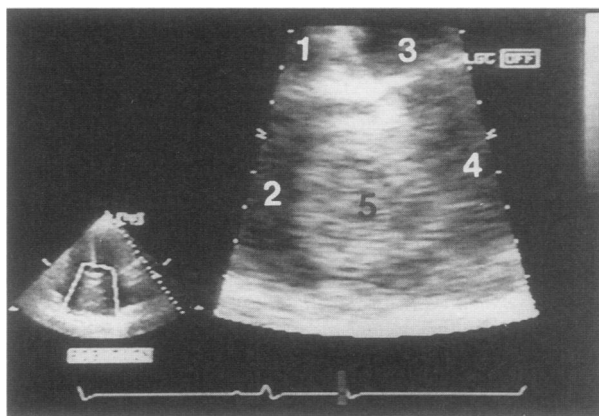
Transthoracic echocardiography shows the cardiac hemangioma in the left atrium.
